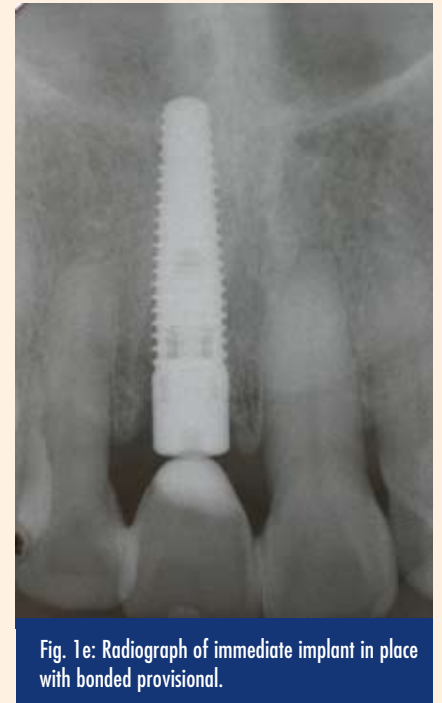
Radiograph of immediate implant in place with bonded provisional.
